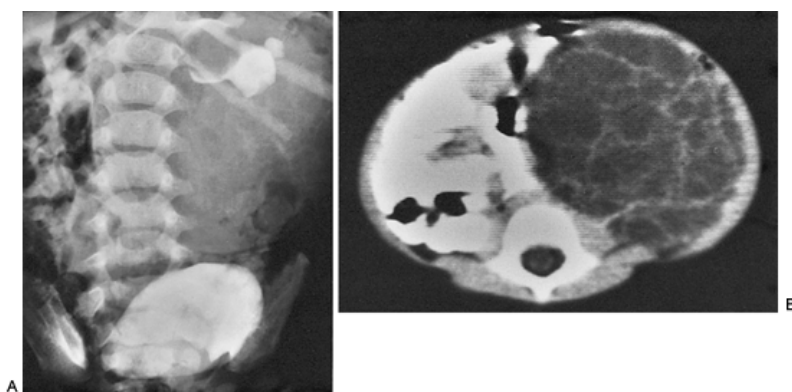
Cystic nephroma in a 4-year-old boy. A: KUB shows mass effect. B: Computed tomography scan with contrast reveals enhancing septa.
